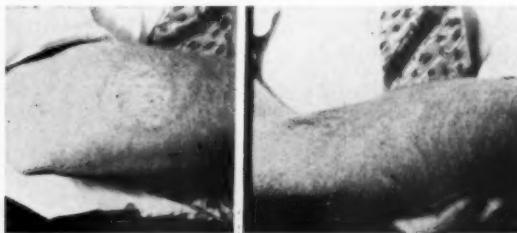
Human skin twelve months after radiation Sept., 1927. On right arm note area radiated and incompletely neutralized, devoid of hair. The same area on the left arm received the same x-ray dosage and was carefully neutralized. No visible changes.
